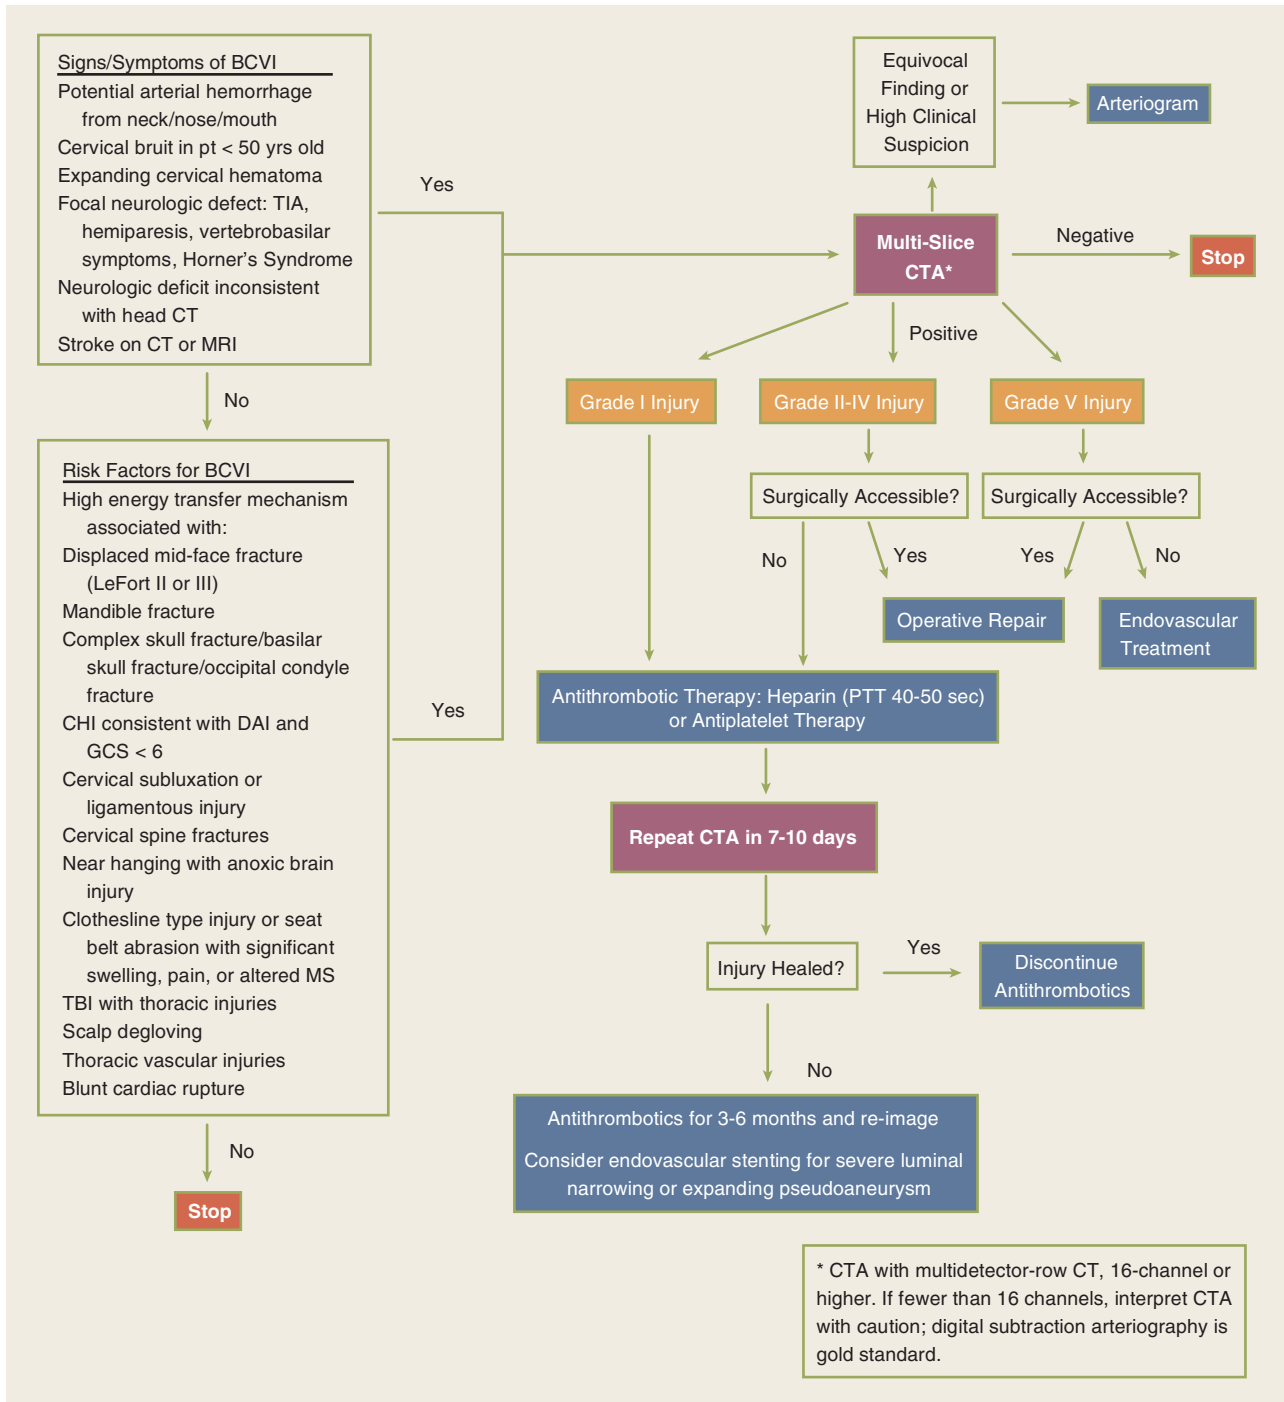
Screening and treatment algorithm for blunt cerebrovascular injuries (BCVIs). Angio = angiography; ASA = acetylsalicylic acid; BRB = bright red blood; CHI = closed head injury; C-spine = cervical spine; CT = computed tomography; DAI = diffuse axonal injury; GCS = Glasgow Coma Scale score; MRI = magnetic resonance imaging; MS = mental status; Neg = negative; pt = patient; PTT = partial thromboplastin time; TIA = transient ischemic attack.
